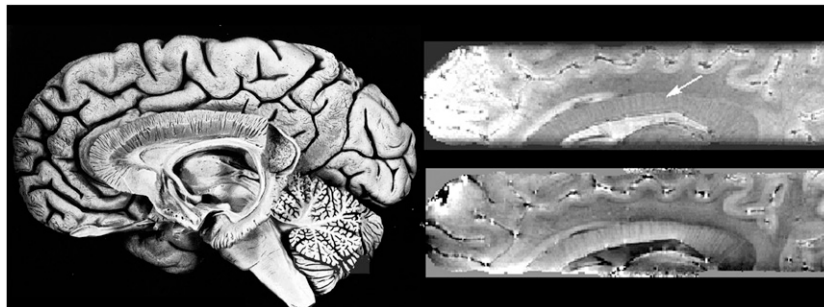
Comparison of the *ex vivo* preparation (left) of Ludwig and Klingler¹⁶ (reproduced with kind permission from S. Karger AG, Basel) with 7.0-T gradient echo magnitude (upper right) and phase (lower right) MRI data. The laminar structure of the corpus callosum is clearly visible in the photograph and a similar pattern appears in the MR images.
